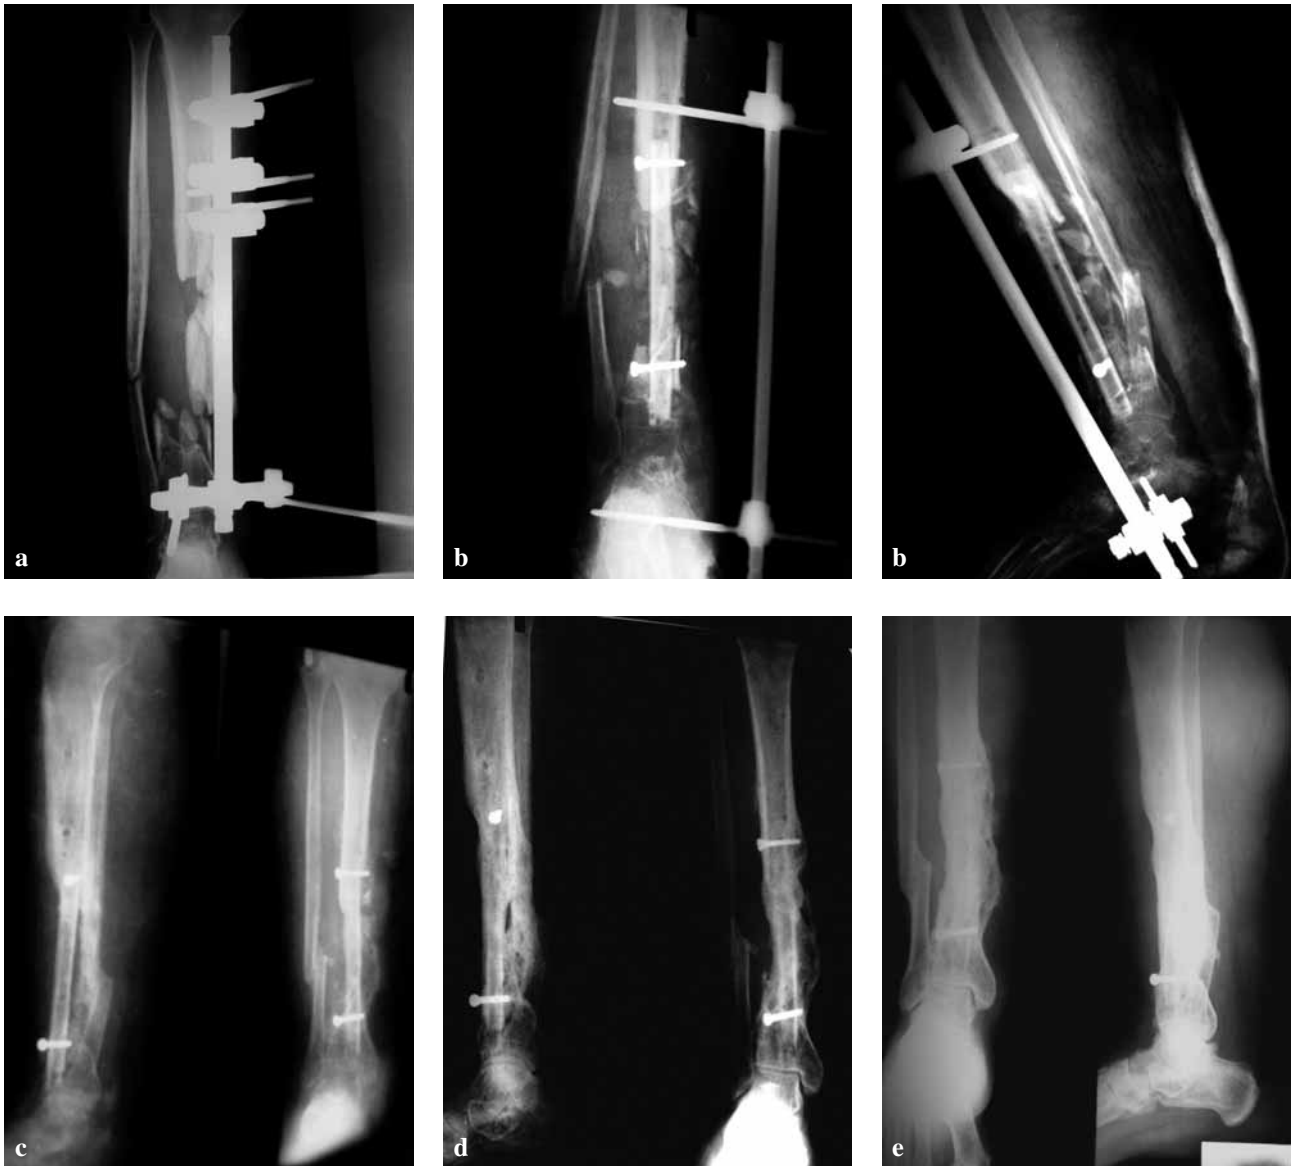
(a) : This 40-year-old male presented with an open comminuted fracture of both bones of his left leg with a tibial bone defect of about 6 cm. (b) : Debridement was done and the patient was prepared after two weeks for operative management of the tibial defect by a free non-vascularised fibular graft that was augmented by an external fixator ; (c) : The fixator was removed 20 weeks postoperatively ; (d) Twelve months postoperatively, radiographs showed union at both ends of the fibular graft ; (e) : Radiographs 4.5 years after treatment showed hypertrophy and tibialisation of the fibula.
